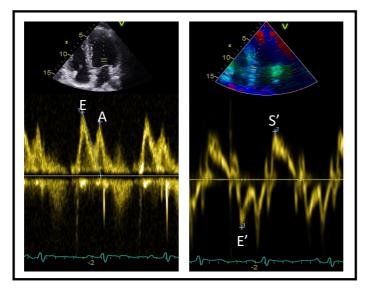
Echocardiography measurement of E/A, E/E' and S'.
